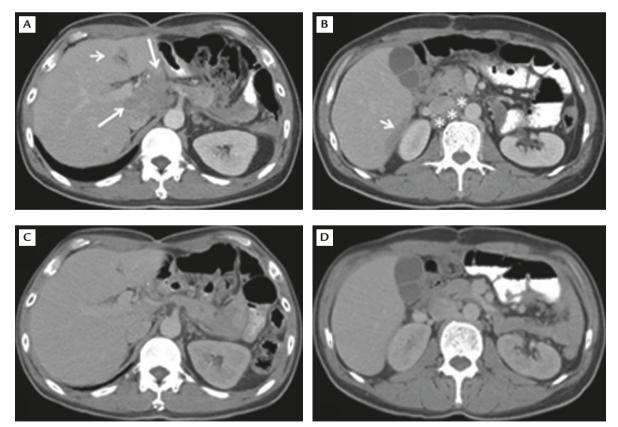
Abdominal computed tomography scans: (A, B) before and (C, D) 3 months after chemotherapy. (A) Hepatic hilar nodes (long arrows) and left hilar fissure node (short arrow). (B) Aortocaval and retrocaval nodes and tumor seeding over the right subhepatic region (arrow). (C) and (D) show remarkable reduction of the tumor along the liver surface and of the lymph node metastases.
